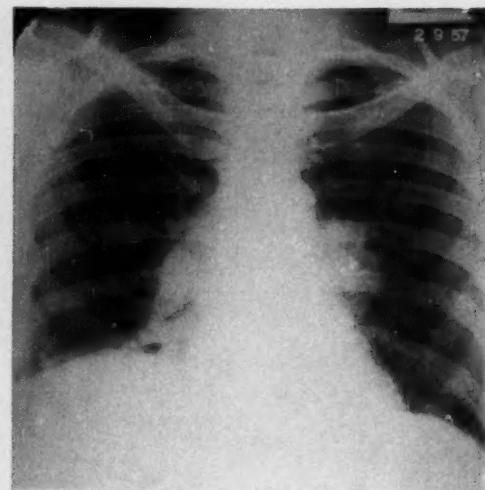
Case 14. Radiographic appearances about time of lung biopsy, showing bilateral hilar node enlargement and clear lung fields.
